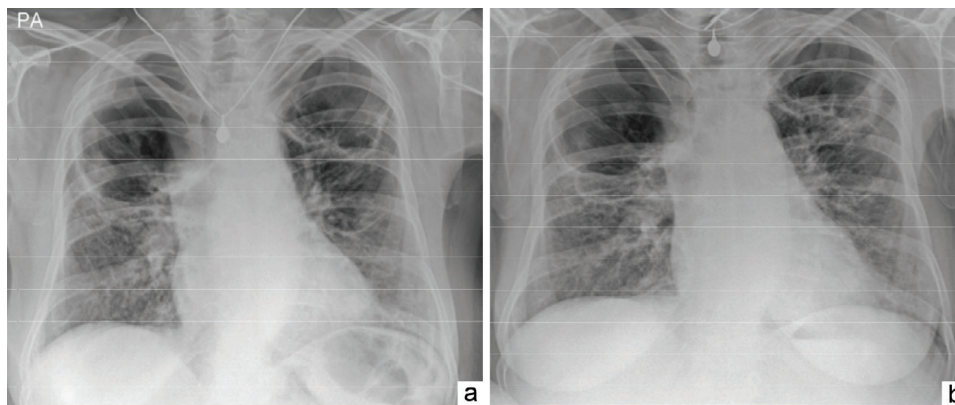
X-rays of the patient's chest organs dated 03.12.2021 (a) and 25.01.2022 (b)
